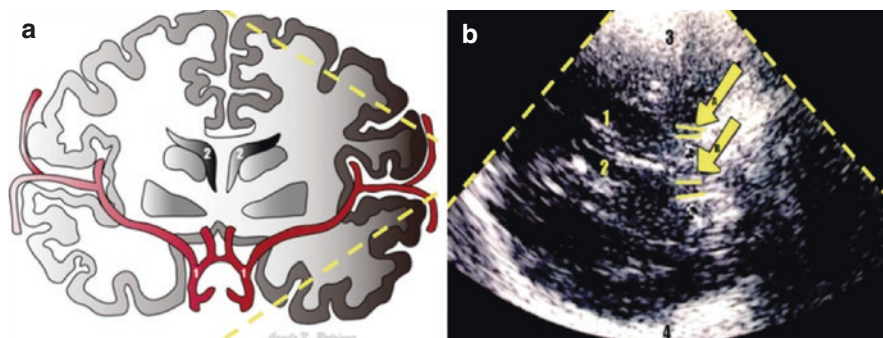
(a) Scheme: Anatomical coronal section; (1) C1 segment of ICA, (2) Frontal horns of lateral ventricles and (Yellow Dotted line) coronal ultrasound beam. (b) Anterior coronal plane through transtemporal window by TCCS approach: (1)(2) frontal horns of lateral ventricles, (3) brain parenchyma proximal to the probe, (4) contralateral skull. (A) Yellow arrows: carotid Groove of the sphenoid bone (C1 segment of Internal carotid artery (ICA))
